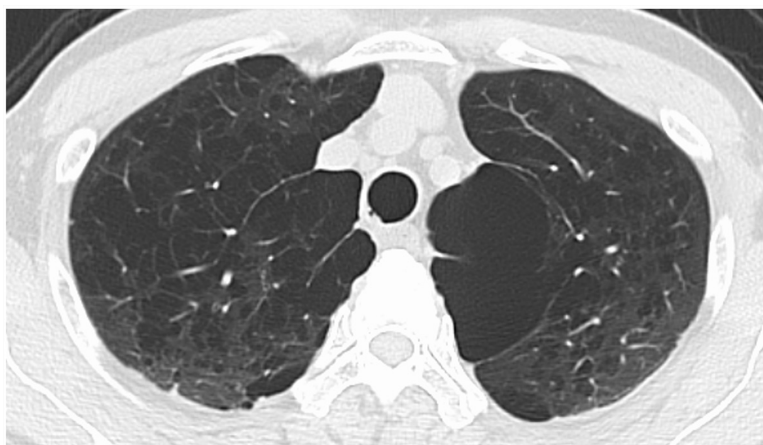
Preoperative chest computed tomography scan of the patient with chronic obstructive pulmonary disease (case 3).
